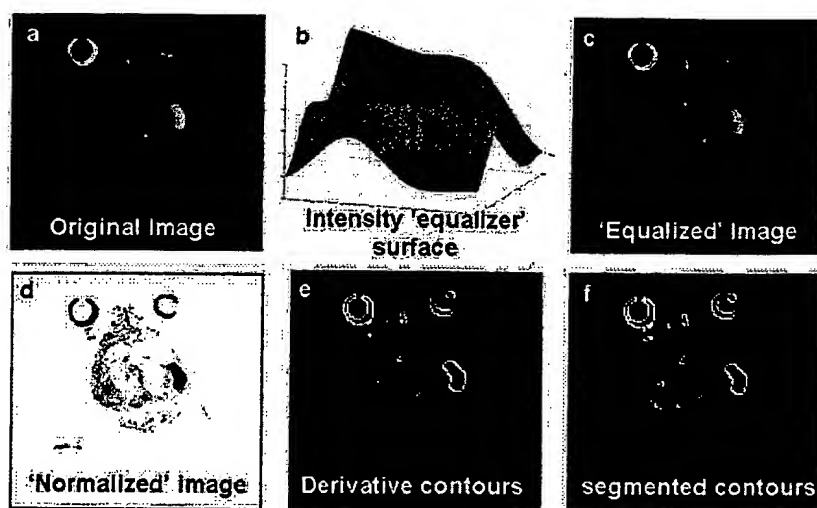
Magnetic resonance imaging analysis. (a) Original image: spin echo, T2-weighted image with TR/TE = 4000/80, two averages, FOV 2.5×2.5 cm, and matrix size 128×128 pixels. (b) Block-averaged two-dimensional surface for background intensity equalization, averaged over 16×16 pixels and interpolated. (c) Background equalized image: the image was equalized by subtraction of the background surface from the original image. (d) Normalization of the intensities within each slice. (e) Boundaries of "patches," obtained by applying the derivative operator over the image. (f) Map of segmented contours, defined by segmenting the detected contour points using a threshold that was defined by the c-means algorithm.
